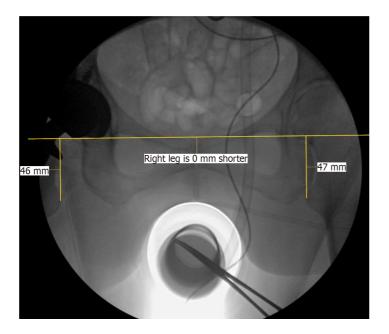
Intra-operative fluoroscopy image capture. Representative image of observer obtained leg length discrepancy measurements on a saved intraoperative fluoroscopic view of the pelvis. Image capture was performed by the OEC image intensifier intra-operatively as described. Shown is a line drawn through bilateral radiographic teardrops with perpendicular lines to the medial prominence of bilateral lesser trochanters.
